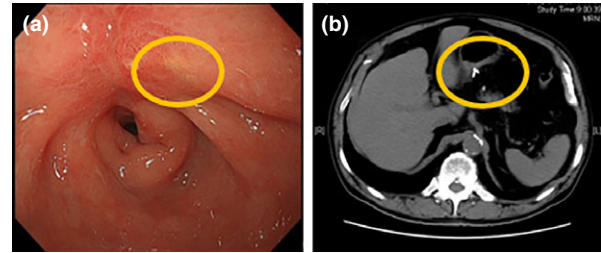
(a) Follow-up endoscopy shows a re-epithelialized post-endoscopic submucosal dissection ulcer and a white substance embedded under the scar. (b) Follow-up computed tomography shows the clip embedded into the gastric wall.
